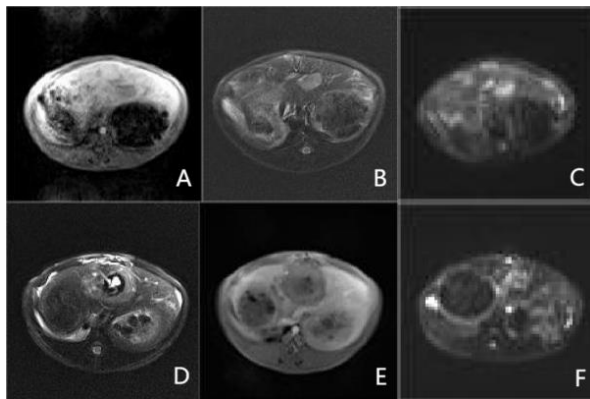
MR guided microwave ablation. A, B, C: Preoperative T1WI, T2WI and DWI images show the tumor lesion in the left lobe of the liver. The lesion is of low signal intensity on T1WI sequence, high signal intensity on T2WI sequence, and high signal intensity on DWI sequence. D: Intraoperative T2WI sequence shows that the ablation needle tip passes through the lesion and the ablation area is basically inclusive of the focus. E: Postoperative T1WI shows a low signal in the ablation area. F: Postoperative DWI sequence shows reduced signal intensity in the lesion.
